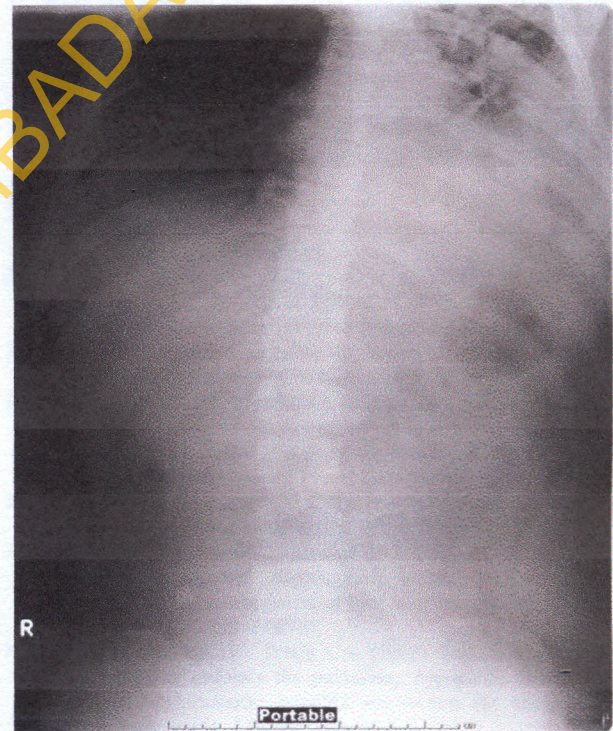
Traumatic hernia of the diaphragm in a 15-year-old boy with acute chest pain and vomiting after competing in a cross-country race. Radiograph of the upper abdomen shows herniation of the bowel and malpositioned nasogastric tube in the left hemidiaphragm
